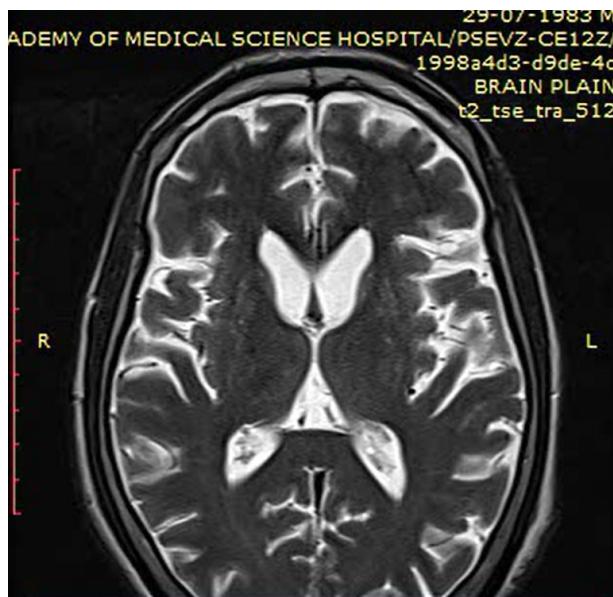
MRI brain (coronal T2-weighted image) showing mild bilateral caudate and lentiform nucleus atrophy with prominent ventricular system and cortical atrophy. These findings are consistent with neurodegenerative changes observed in Chorea-acanthocytosis (ChAc).
